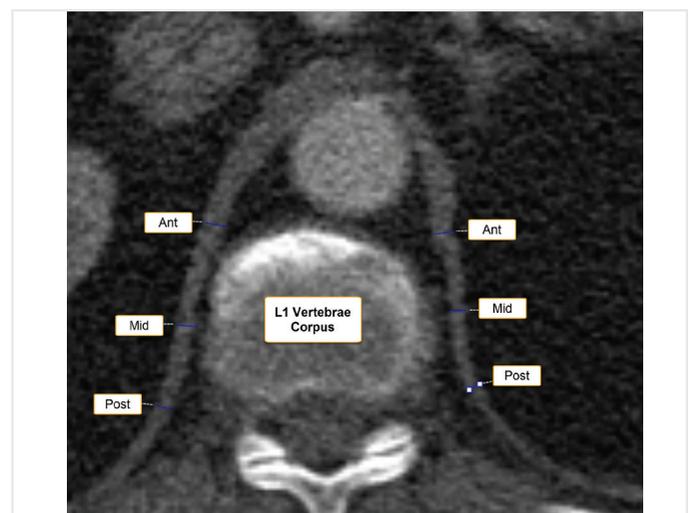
b) Axial computed tomography scan at the L1 vertebrae corpus level shows anterior, mid and posterior diaphragm thickness measurements
